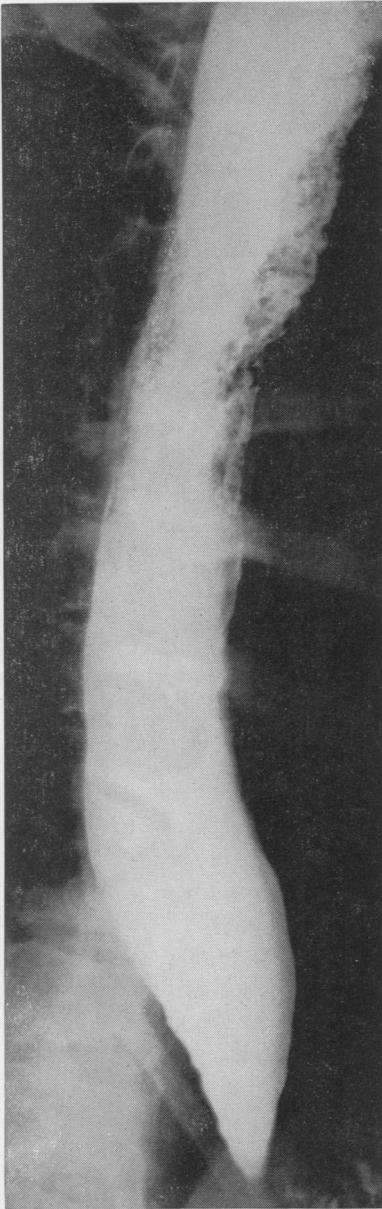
Roentgenogram of patient with achalasia showing cylindrical or fusiform dilatation of the esophagus.
